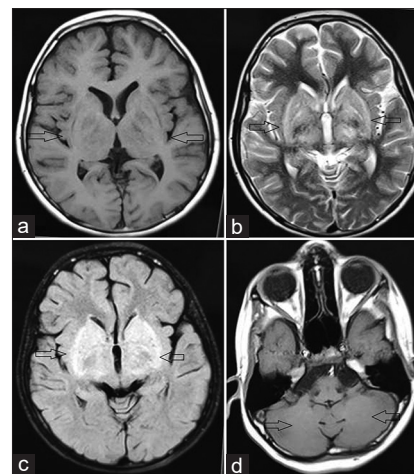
Magnetic resonance imaging brain axial cuts, (a) T1 image (calcified areas are of high signal), (b) T2 image (calcified areas demonstrate low to isointense signal), (c) fluid-attenuated inversion recovery image and (d) T1 image showing bilateral symmetrical strio-pallido-dentate calcification
